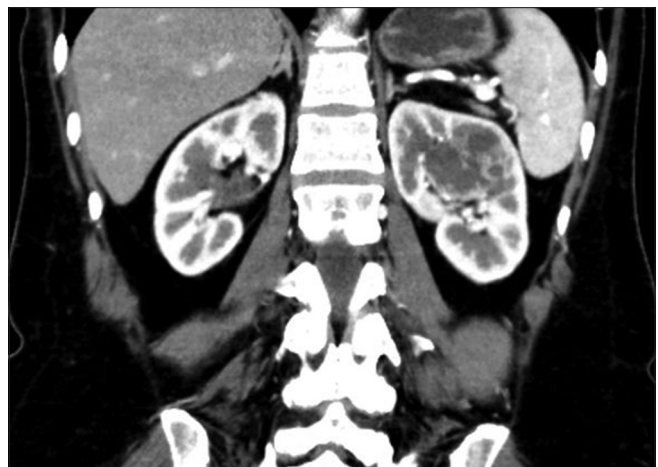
Endogenous kidney neoplasm imaging in computed tomography arterial phase
